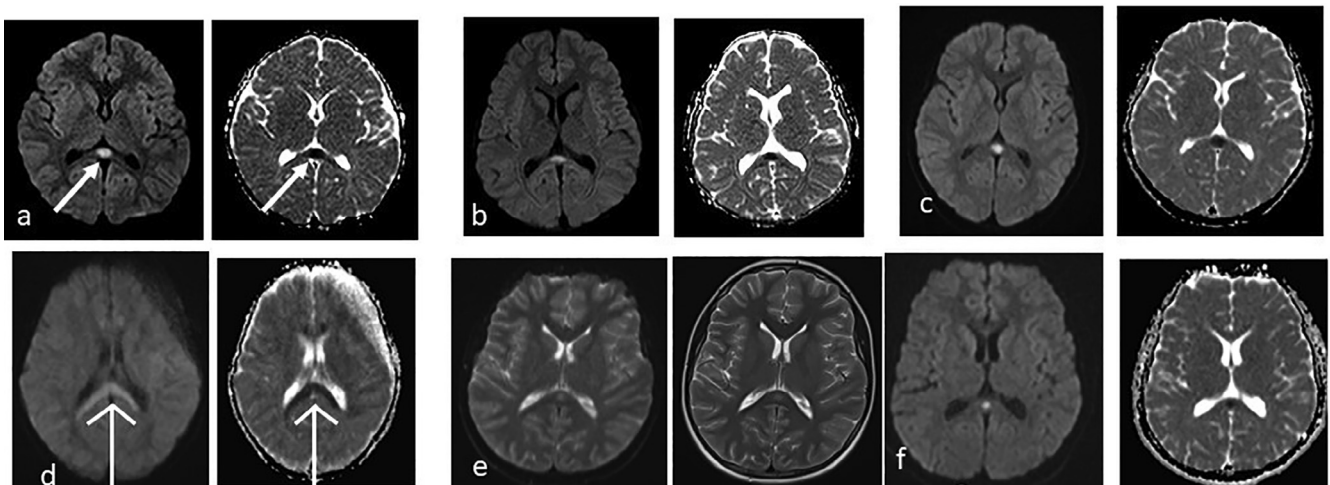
Examples of infection-associated CLOCCs on diffusion and apparent diffusion coefficient weighted cranial MRIs, ovoid-shaped (a,b,c) is more common although lesions extending through the callosal fibers laterally into the adjacent white matter (d) can be encountered. Only lesions in figures (a) and (d) are represented with arrows to orient readers. Diffusion and T2 weighted MRI of patient 22 in Table 2 with COVID-19 associated multisystem inflammatory syndrome (e). Diffusion weighted MRI of patient 23 in Table 2 with COVID-19 is shown (f).
